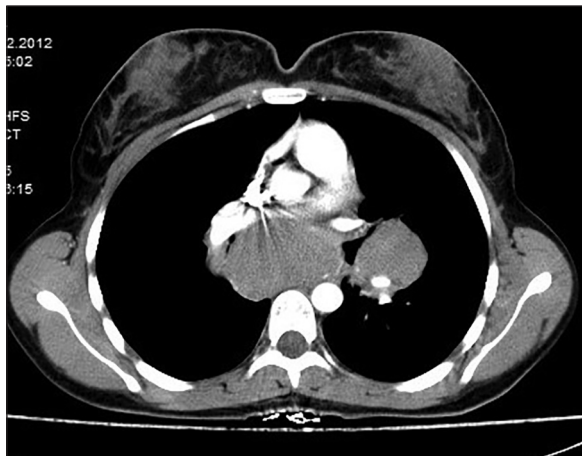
Mediastinal lymphadenopathy on thorax CT
